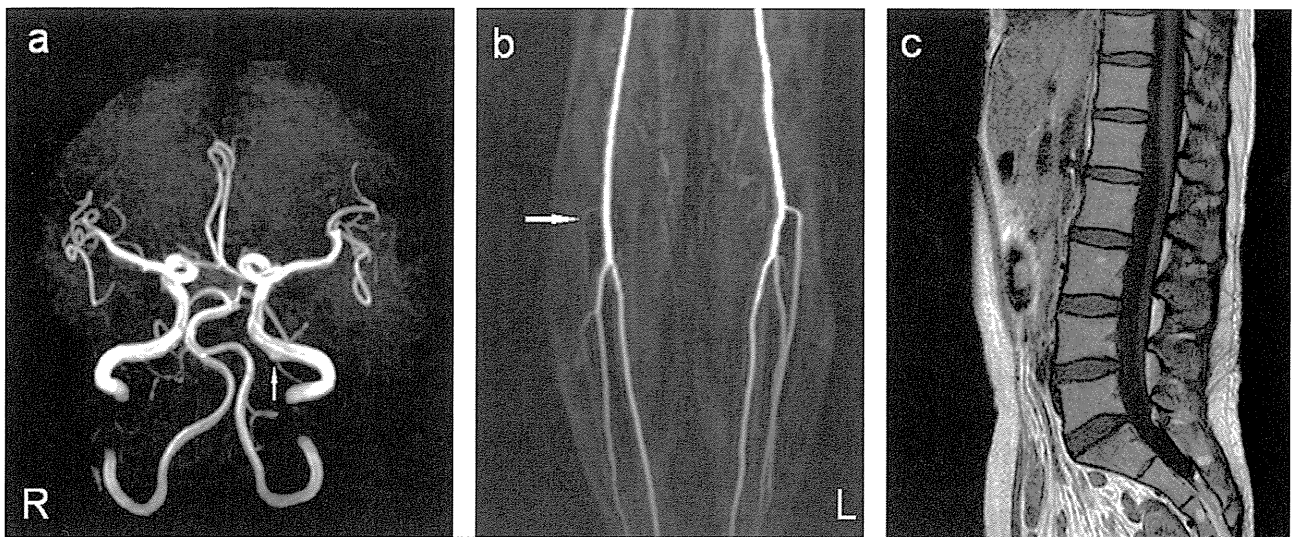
(a) Magnetic resonance angiograph of the brain showing tortuous vertebral and basilar arteries and a mild bulging of 4-mm width suspected to be an aneurysm at the left carotid canal (arrow). (b) The arrow indicates hypoplasia of the right anterior tibial artery without stenosis or obstruction. (c) Magnetic resonance image of the lumbar spine and cord showing dural ectasia.
